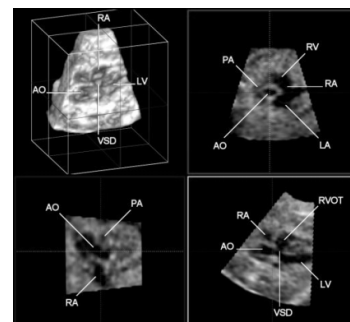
An example of 4D ultrasound scan
